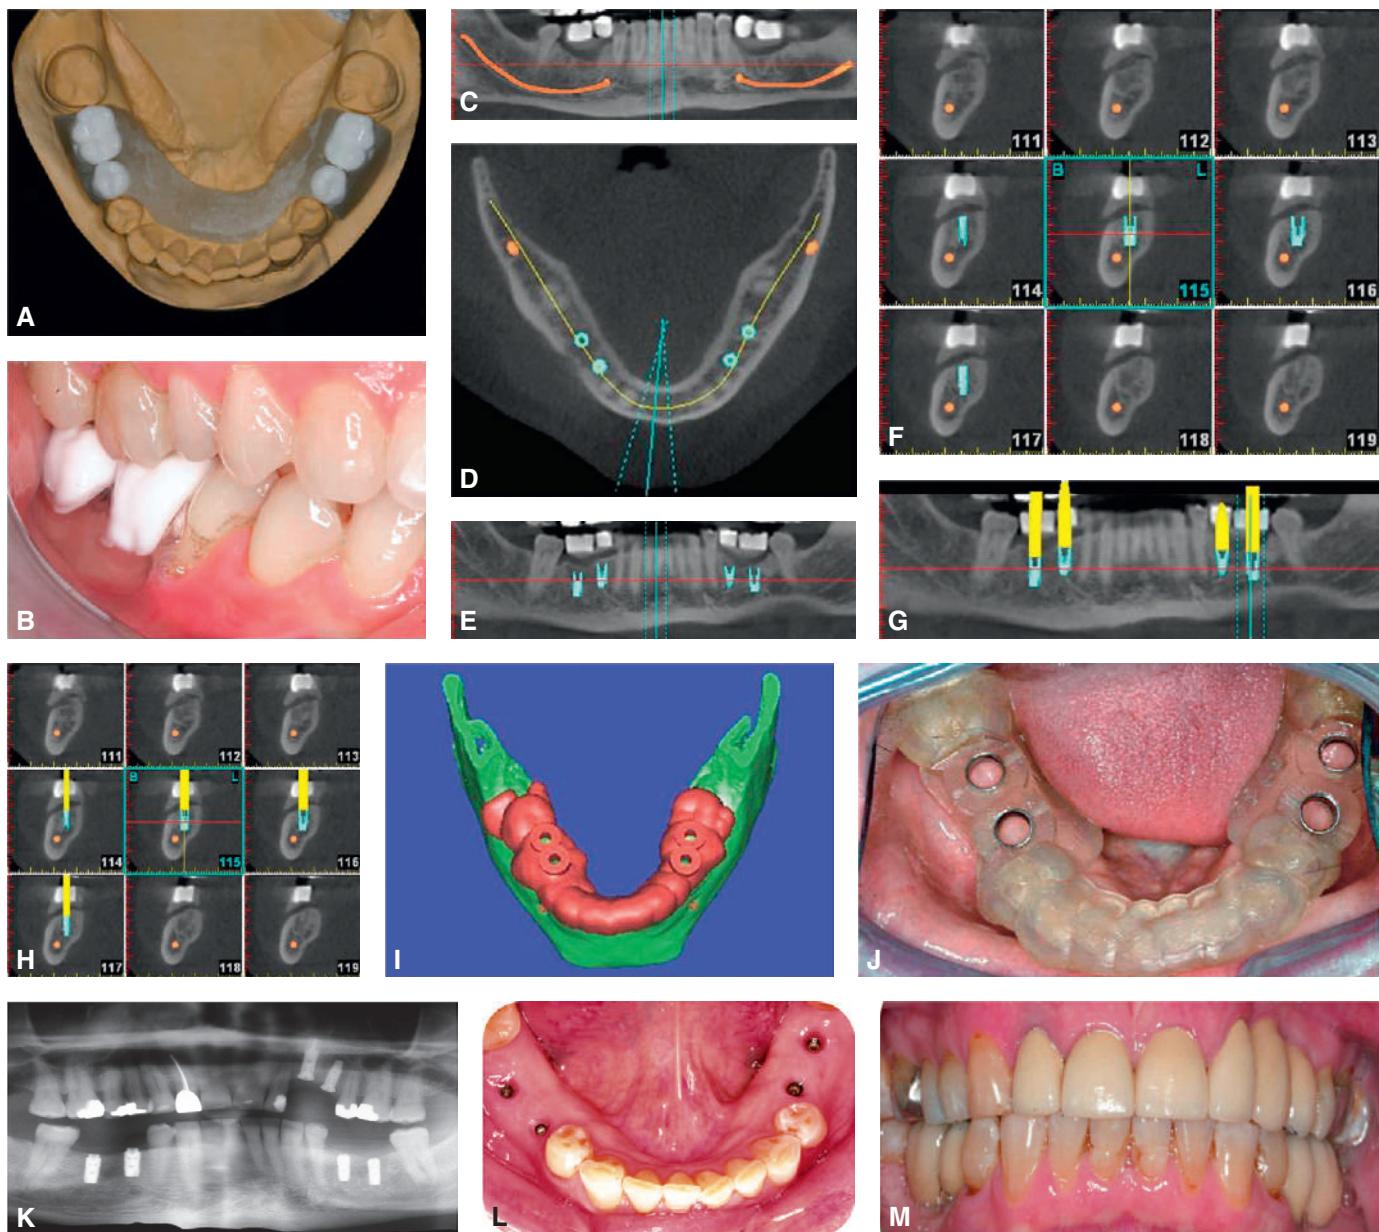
Computed tomography (CT). (A) Scan guide with barium-impregnated teeth. (B) Scan guide positioned in the mouth. (C) Barium-impregnated teeth in the scan. (D) Scan with lines orienting the position of transverse mandibular cross-sections. (E and F) Reformatted cross-section of the posterior part of the mandible. Software program allows visualization of prospective implant placement. (G and H) The software program allows for placement of abutments for predictable prosthetic positioning. (I and J) CT-generated surgical guide design generated by software program (I) and the intraoral view (J). (K) Panoramic radiograph. (L) Intraoperative view of implants. (M) Intraoperative view of definitive restorations.
